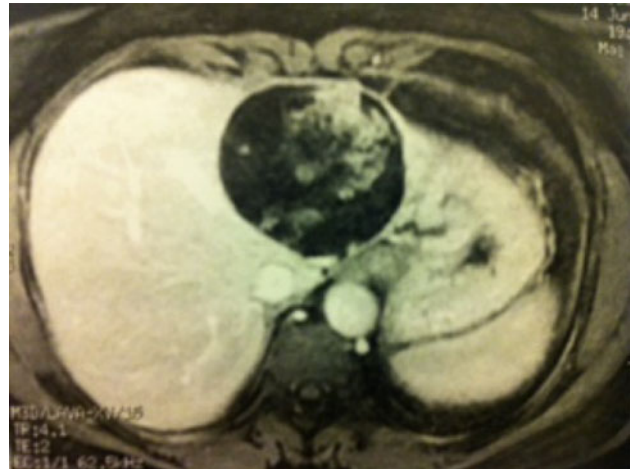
Magnetic Resonance Magnetic (MRI) showing a cystic mass in segments II and III of the liver with hemorrhagic contents in the lumen
